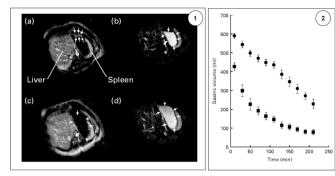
1) Echo-planar magnetic resonance images acquired across the body of the stomach of one volunteer at t = 40 min after ingestion of the acid-unstable fat emulsion meal (a and b) and the acid-stable fat emulsion meal (c and d). The imaging inversion time in (a) is set to null the bulk water phase of the acidunstable meal and a fat layer (indicated by the white arrows) can be clearly seen floating on top of the stomach for this meal. In the corresponding image for the acid-stable meal (c) no fat layer is observed and the stomach contents yield a low fat background signal (indicated by the white arrows) that appears to be homogeneous. In (b) the imaging inversion time is set to null the fat layer of the acid-unstable meal. The bulk water phase (indicated by the white arrows) can now be seen very bright. In the corresponding image for the acid-stable meal (d) the bulk water phase, indicated by the white arrows, appears less bright than in (b). 2) Gastric emptying patterns (gastric meal volumes  $\nu$ . time) of ( $\bullet$ ) acidstable and (■) acid-unstable emulsions as analysed by echo-planar magnetic resonance. The gastric half-emptying time of the acid-unstable emulsion meal was faster than that of the acid-stable emulsion. Adapted from Marciani, Faulks, Wickham, Bush, Pick, Wright, Cox, Fillery-Travis, Gowland and Spiller [91] with permission from Elsevier Inc.
